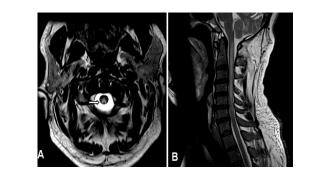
MRI T2 weighted images axial (A) and sagittal (B) sections.
